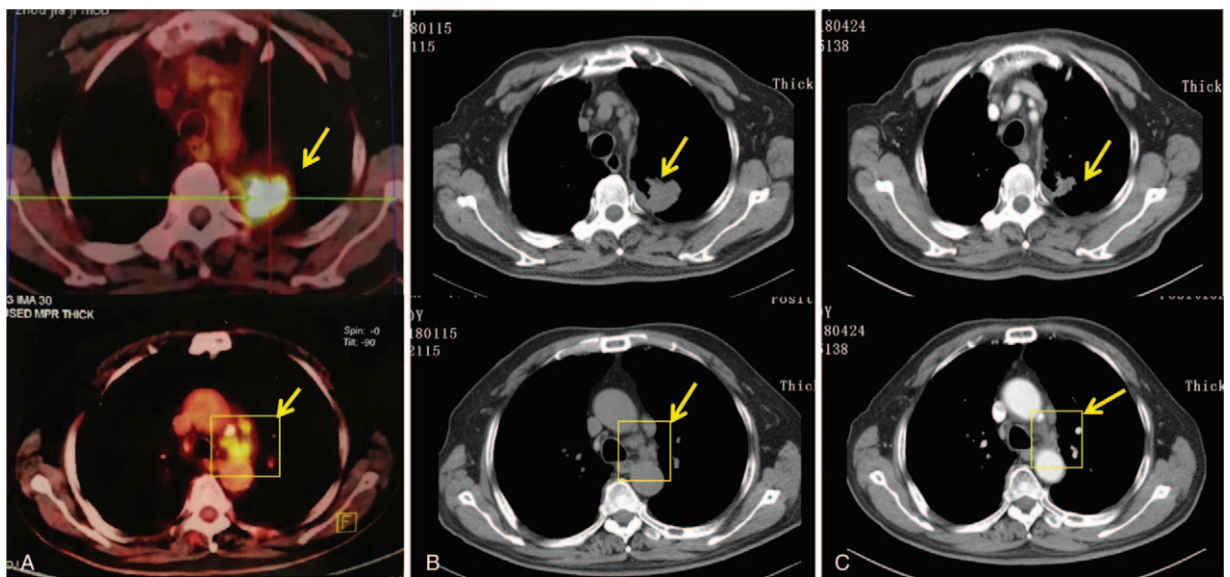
Computed tomography scans of the chest showed: (A) before Icotinib therapy; (B) tumor volume and mediastinal lymph nodes slightly decreased after 1 month of Icotinib; (C) tumor volume and mediastinal lymph nodes significantly decreased, and the patient had a partial response after 5 months of Icotinib. Yellow arrow indicated primary lung mass; yellow arrow with rectangle indicated multiple metastatic lymph nodes.
